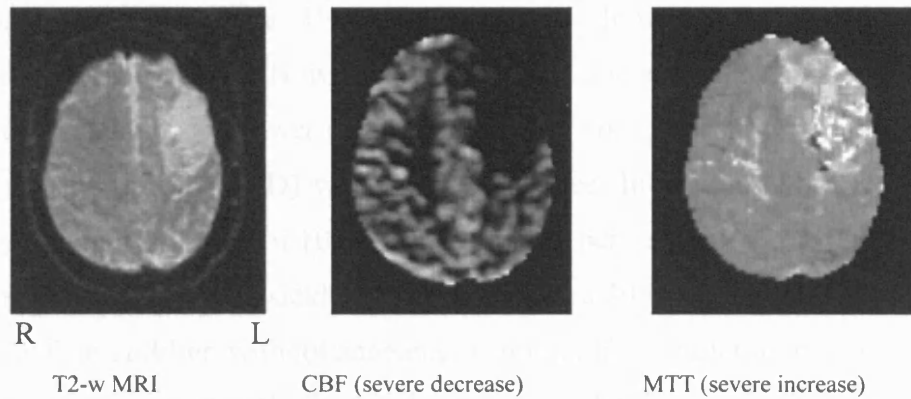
Perfusion MRI (DSC-MRI) in a patient with sickle cell anaemia and stroke. Left frontal infarct on T2-weighted MRI; severe decrease in cerebral blood flow (CBF) or (- - -), severe increase in the mean transit time (MTT) or (+ + +) in the left frontal areas. Cerebral blood volume (CBV) maps are similar to CBF. R; right; L: left.
